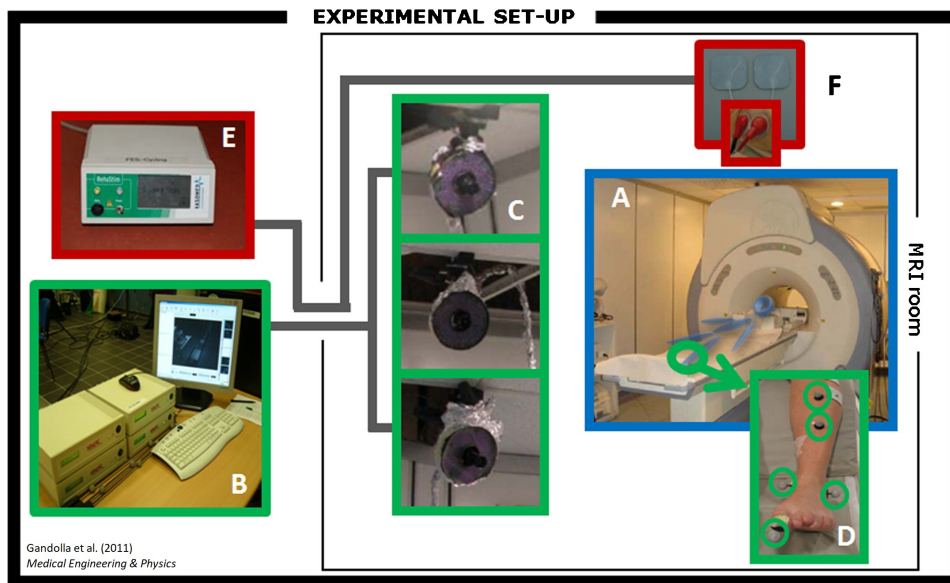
Experimental set-up. (A) MRI scanner CV/I 1.5 T; (B) motion capture system Smart μg with (C) three cameras and (D) reflective markers; (E) FES current-controlled stimulator RehaStim pro and (F) stimulation electrodes.
